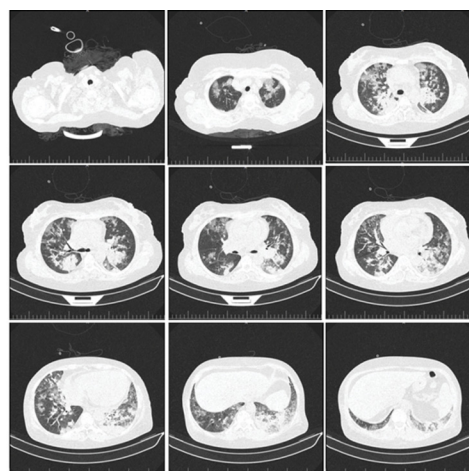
Chest CT-scan before treatment.
